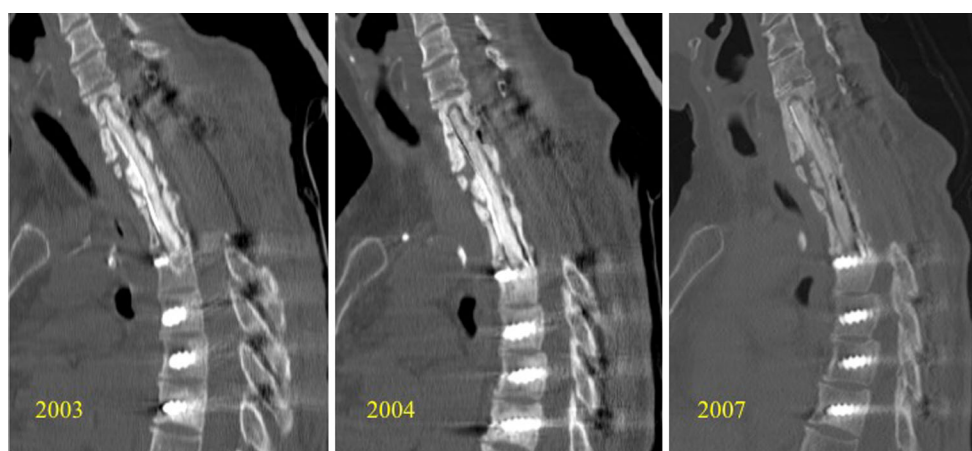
CT scans of the upper thoracic spine confirming showing a well-maintained anterior PMMA spacer with no evidence of failure
